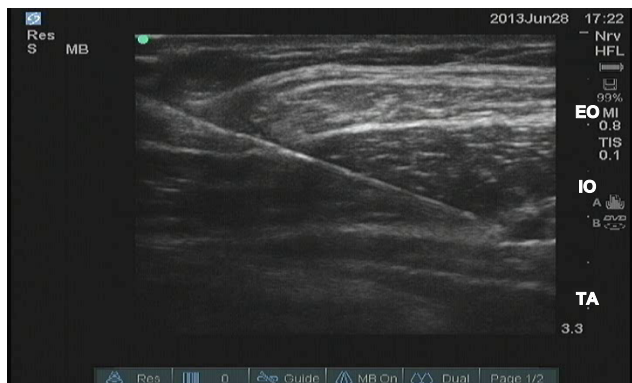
Ultrasonographic view of a 21-gauge 100 mm Stimuplex needle® advancing towards the transversus abdominis plane below the external oblique (EO) and between the internal oblique (IO) and transversus abdominis (TA) muscles.
